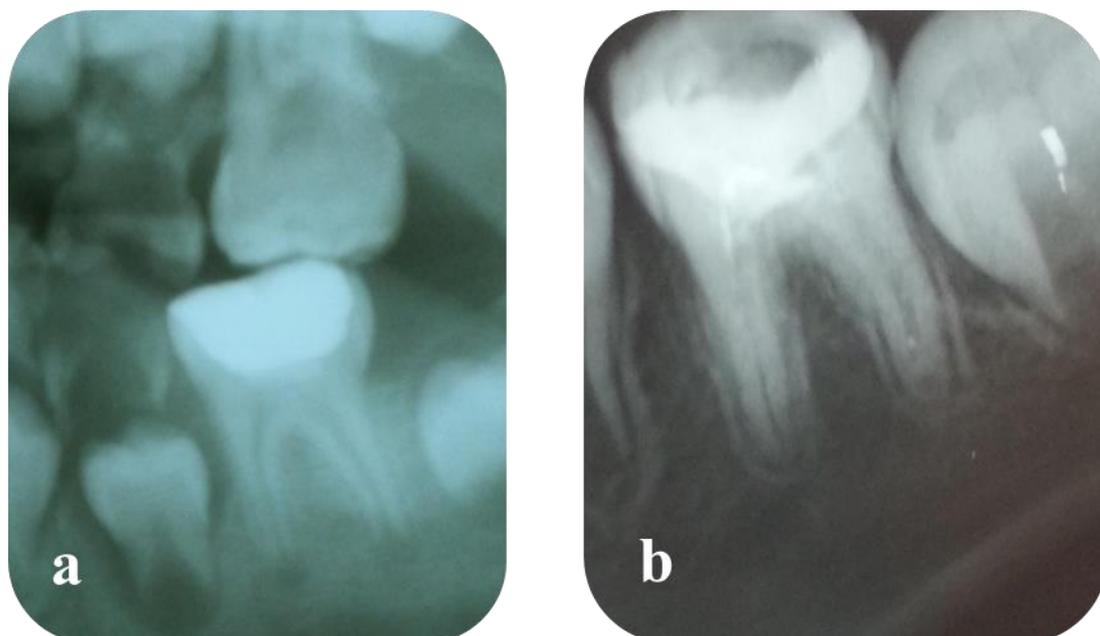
Retroalveolar X-radiography a. after 1 month, b. after 3 months and c. after 6 months following the treatment
